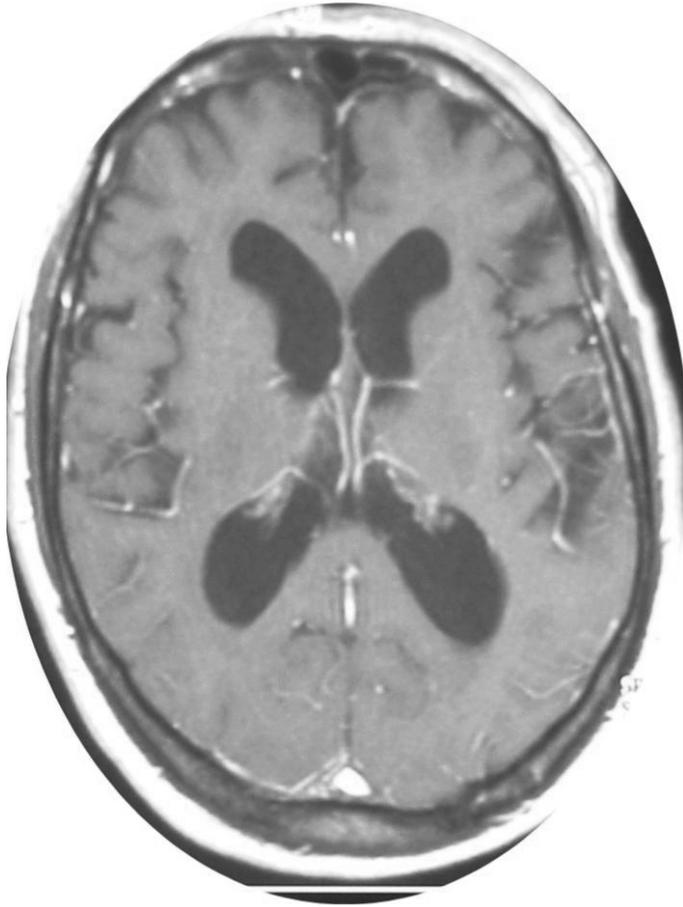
MRI scan of a 78-year-old man who had a severe magnetic gait and was labeled as having Parkinson disease. He eventually became wheelchair-bound. A shunt was inserted, and the patient was walking independently within 3 weeks.
